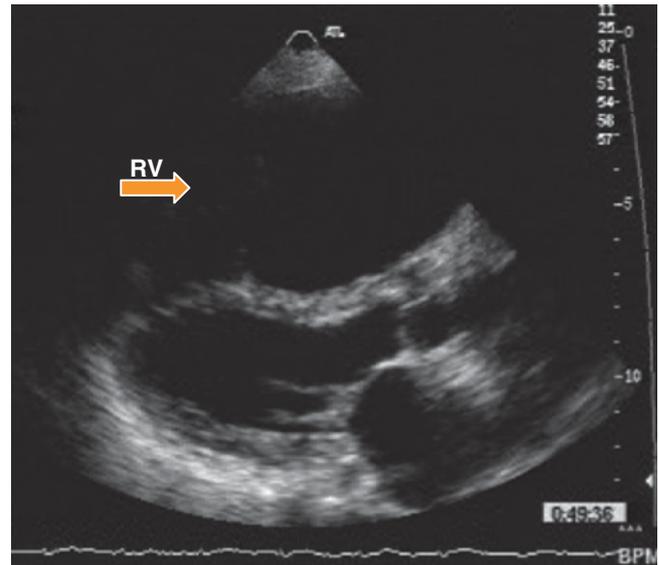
Parasternal long-axis view from a patient with advanced ARVC/D demonstrating a dilated RV (*arrow*) with marked global hypokinesia. Notice that the LV size is normal
